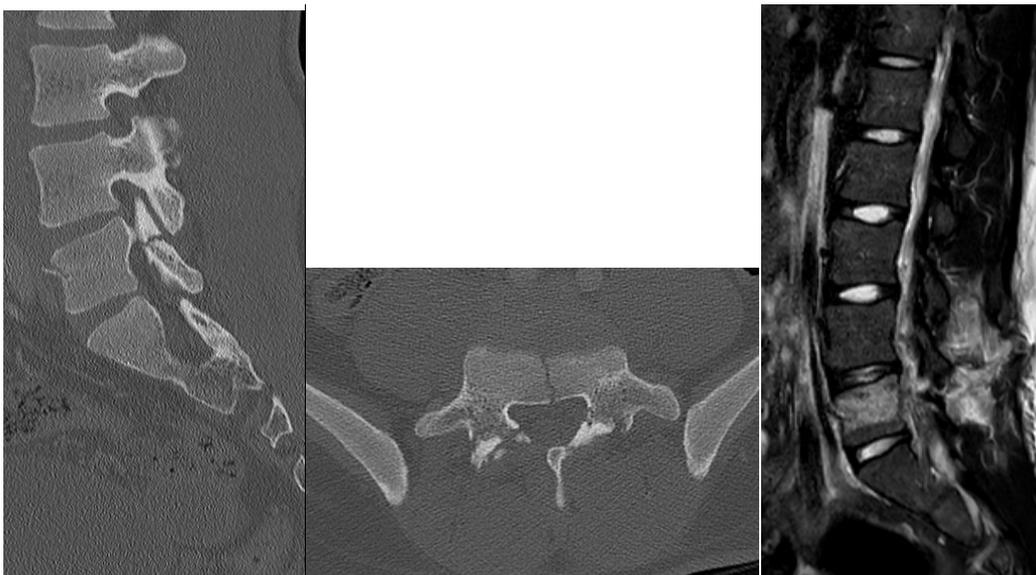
Monosegmental trans-osseous injury (Chance) (three column injury, AO classification: B1, TLICS morphology: distraction – score 4, and PLC status: definite injury – score 4). Sagittal (5a) and Axial (5b) CT demonstrates a fracture across the L5 vertebral body extending into the posterior elements (straight arrows) involving the pars interarticularis. Sagittal STIR (5c) demonstrates disruption of the ALL, PLL, ligamentum flavum, interspinous ligament and supraspinous ligament in keeping with PLC disruption and highly unstable injury.
